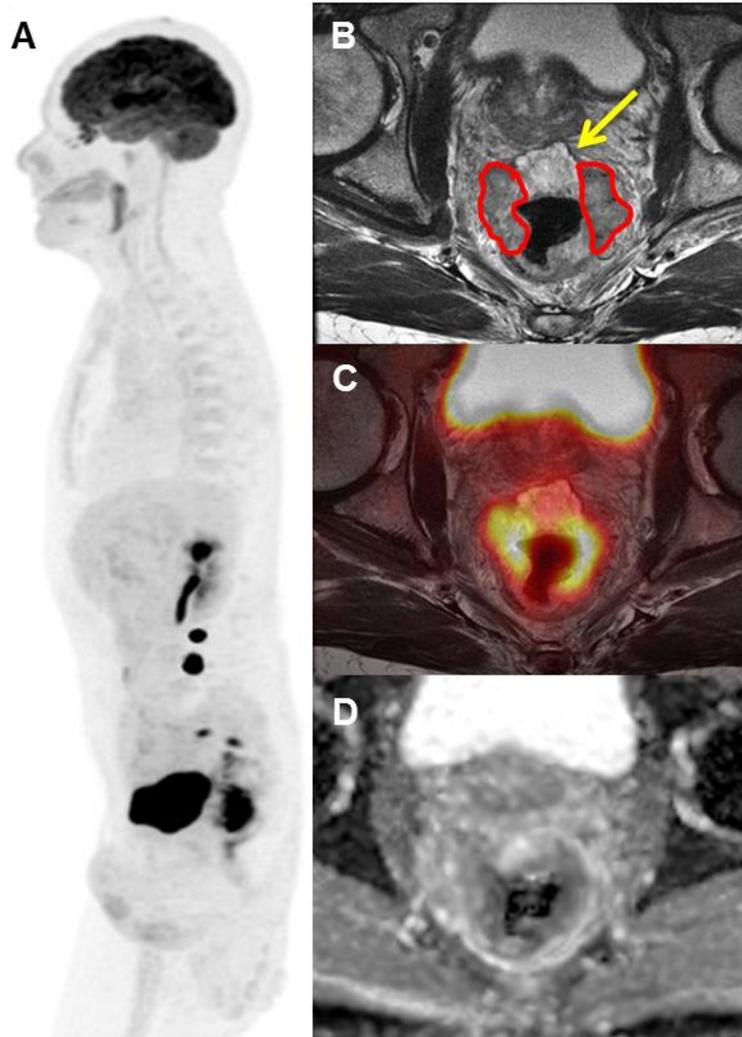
Difference between tumor metabolism and cellularity between MC and NMC within primary rectal tumor. Male, 64 years old, presenting an anterior primary rectal tumor presenting a central MC (yellow arrow on B) with minimum FDG uptake (C) and lateral NMC (curved red circles on B) with intense FDG uptake (C). Note that the difference on restriction diffusion (D) between the MC and NMC is not as intense as the glycolytic metabolism.
